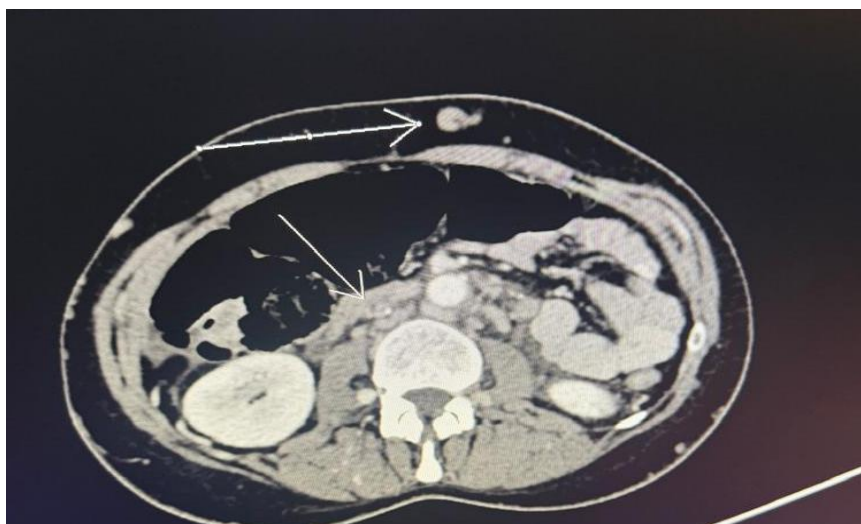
Axial contrast-enhanced CT of the abdomen in the present patient, obtained at the level of the retroperitoneum, showing dilated and tortuous paravertebral and retroperitoneal collateral venous channels (arrows) in the absence of a normal-calibre infrahepatic inferior vena cava, consistent with congenital IVC agenesis/hypoplasia and collateral venous drainage.
